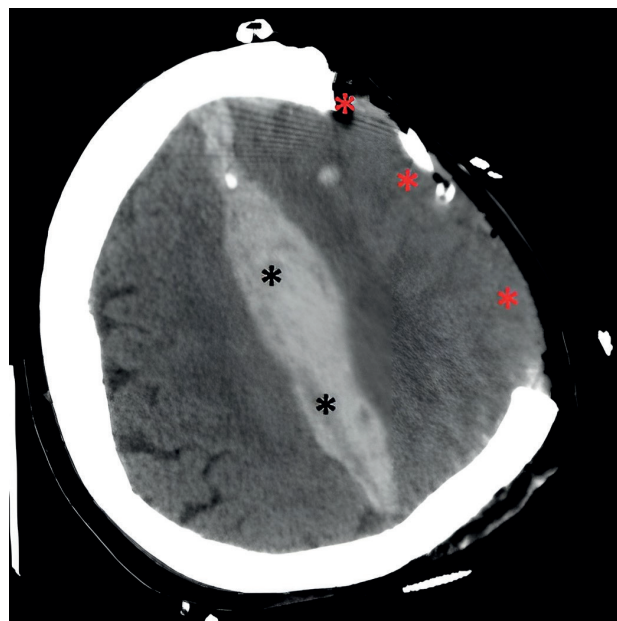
Postoperative computed tomography images of the patient. Craniectomy defect (red asterix). Persisted parafalcine subdural hemorrhage (black asterix).
